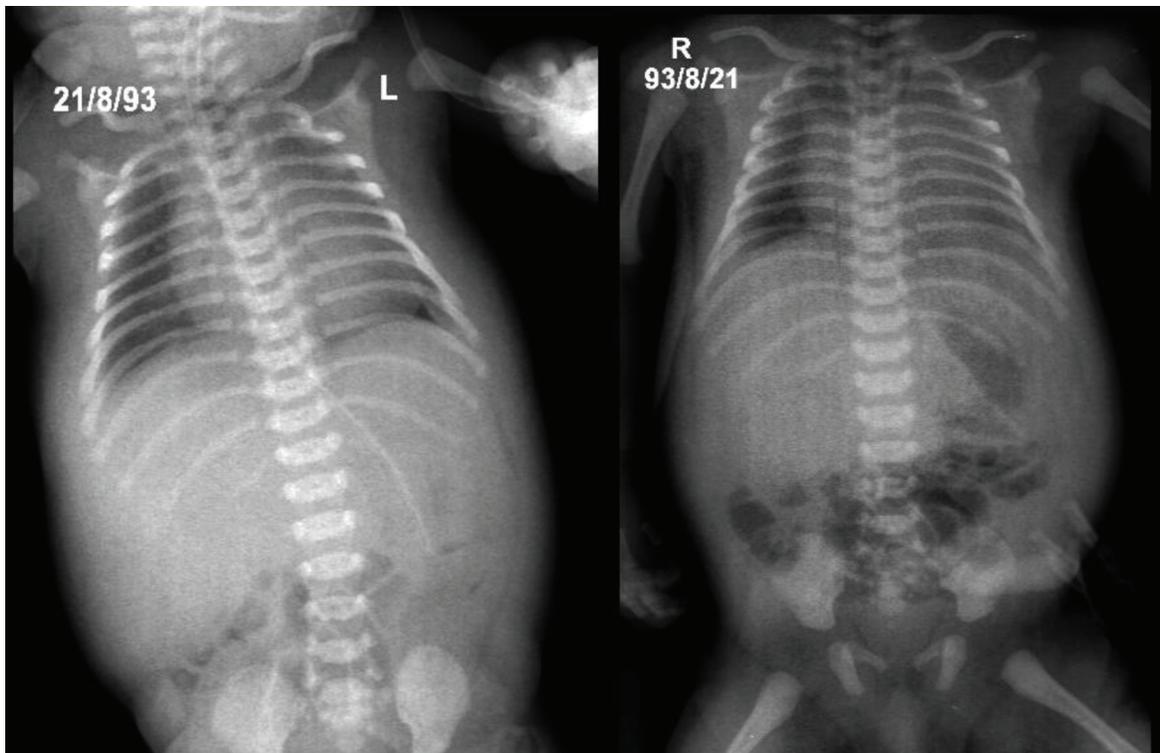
Chest X-ray image obtained before operation showing normal results
